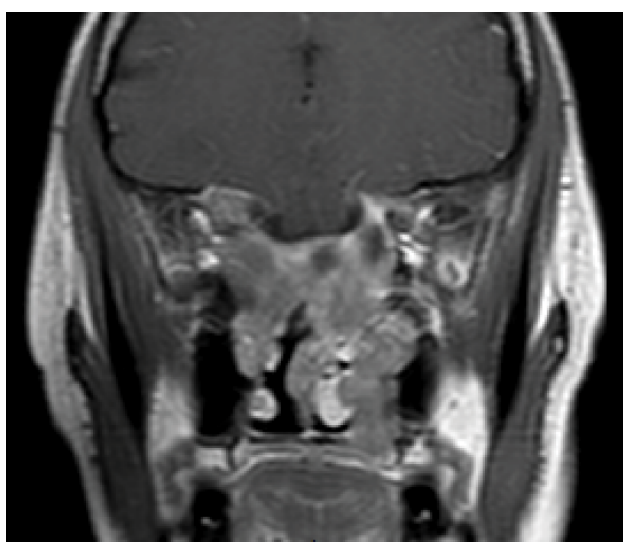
CT scan – Coronal view.
